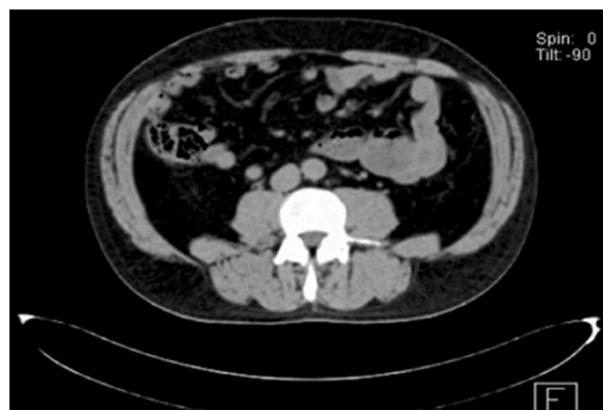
CT, a mass is seen in the bowel.
